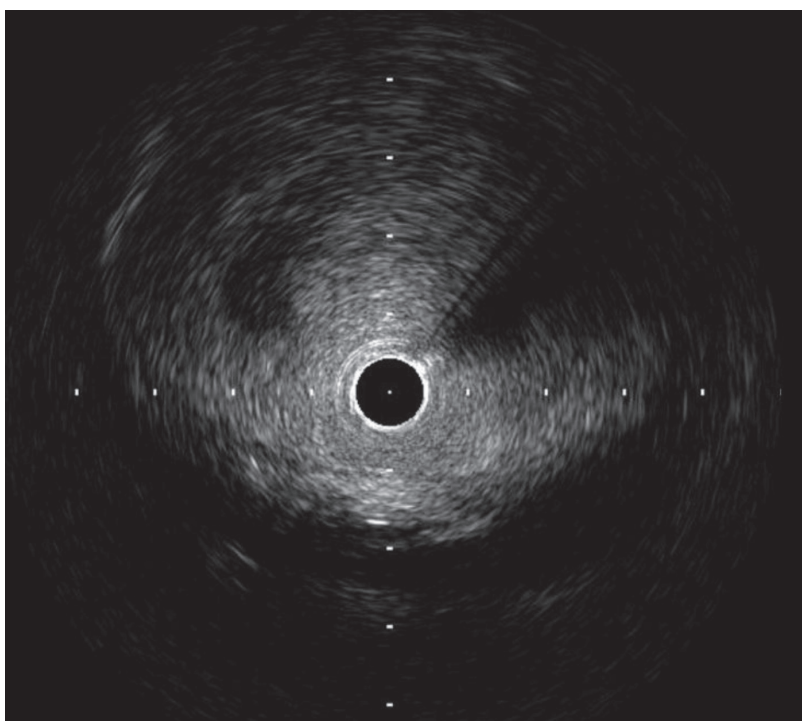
Intravascular ultrasound showed the proximal right coronary artery aneurysm exceeded the scan limit and was filled with thrombus.
